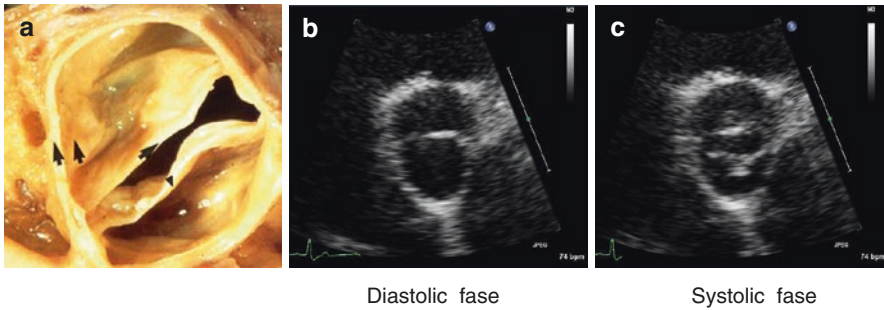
Bicuspid aortic valve (a) Anatomic image of a bicuspid aortic valve, (b and c) Echocardiographic image (parasternal short-axis) from a bicuspid aortic valve in diastole (b) and systole (c)
